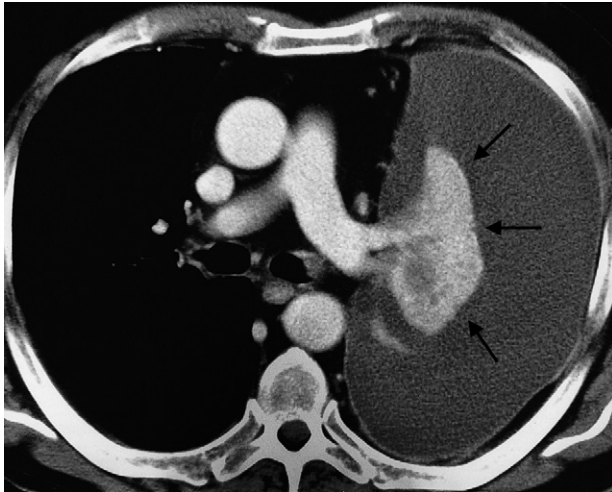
CT showing pleural effusion and pulmonary collapse. The collapsed lobe (arrows) can be clearly seen beneath the large left pleural effusion.
